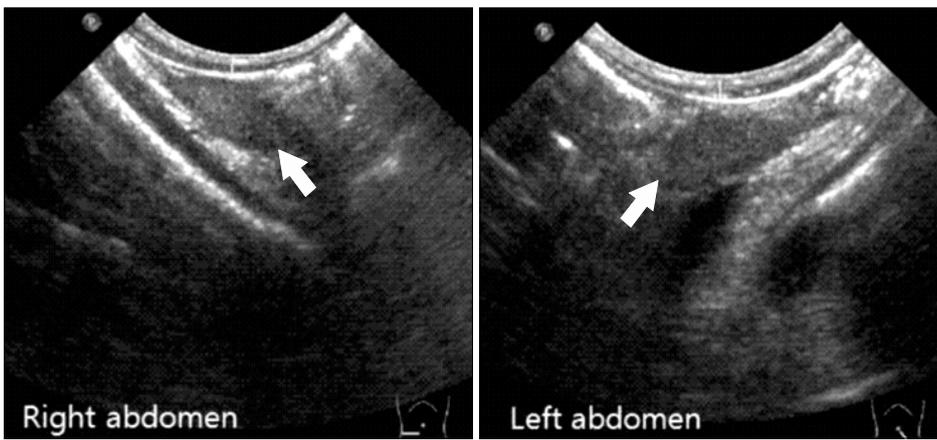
Scrotal ultrasonography showed bilateral testes in the lower abdomen; the testis sizes were 12x6x5 mm and 11x5x5 mm on the right and left, respectively.
